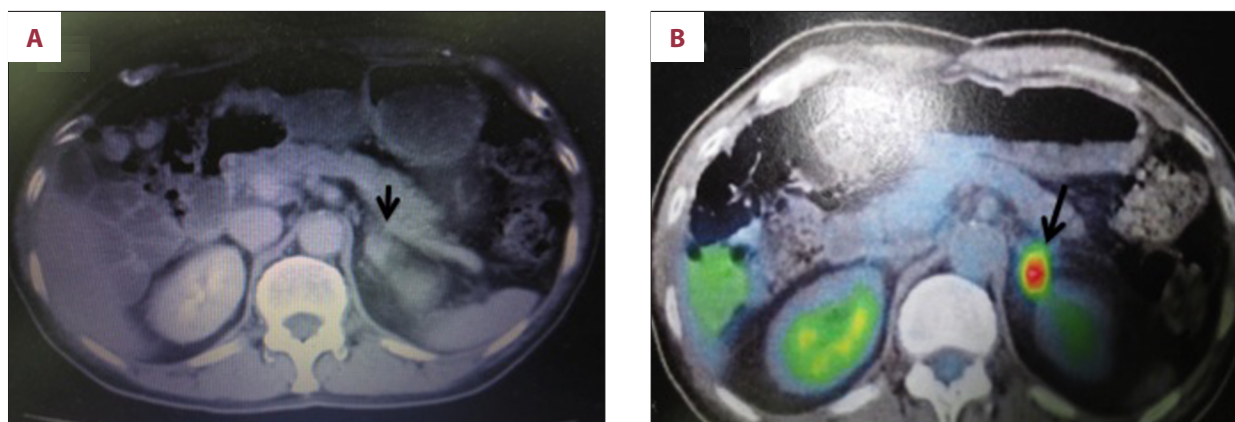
(A) CT performed 1 year after right adrenalectomy shows a left adrenal tumor (2.5×1.6 cm). (B) A PET/CT scan shows a moderate uptake in the tumor, with a maximum SUV of 6.0.
